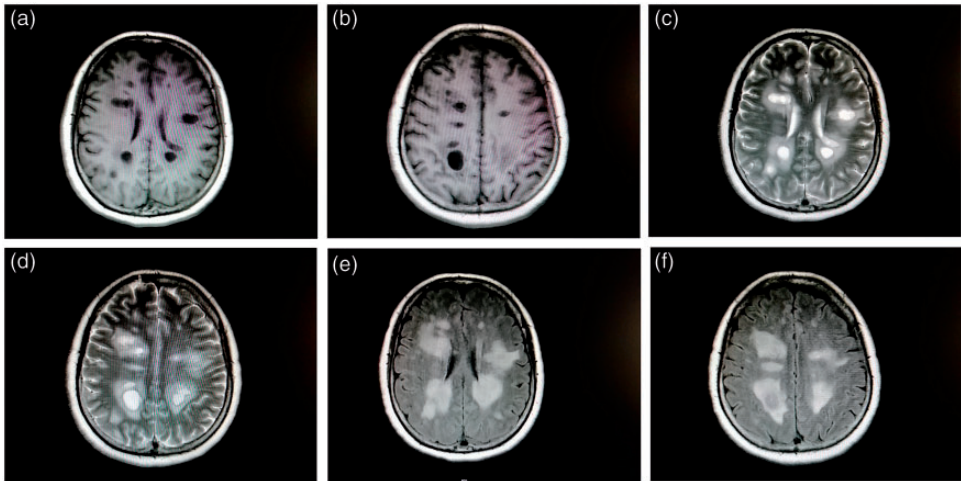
Magnetic resonance images from a female patient, 63 years old, with a clinical diagnosis of sudden deafness and an imaging report of “white matter demyelination degeneration.” a: T2-weighted long-point signal in the parietal frontal lobe. b: Fluid-attenuated inversion recovery (FLAIR) parietal dotlike hypersignal. c: T1-weighted thin-layer long T1 signal at the edge of the dual frontal angle. d: T2-weighted phase-two frontal edge thin-layer long T2 signal. e: FLAIR phase hyperintensity signal on both frontal edges.
